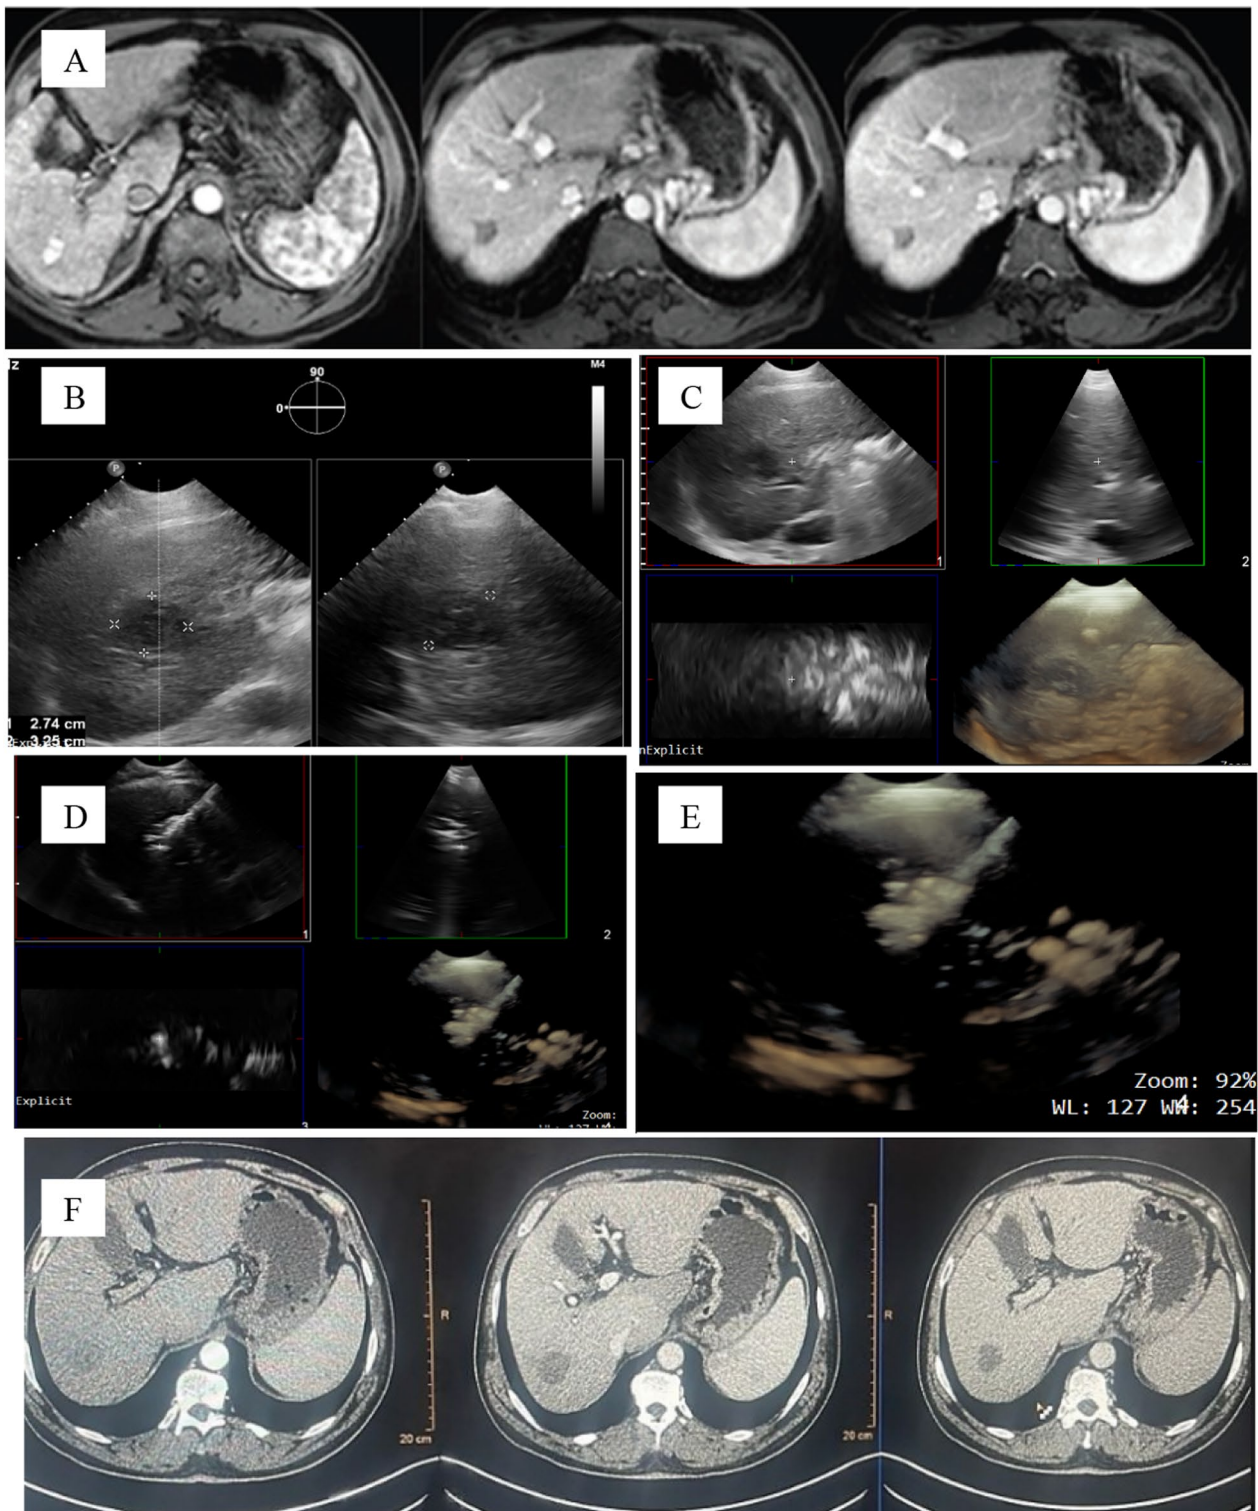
A–F, Case (4): A male patient with a right hepatic lobe segment VII focal lesions 2 × 2 cm, confirmed to be HCC by triphasic CT, A Triphasic CT scan showing arterial enhancement at the arterial phase and washout at the delayed phase, the patient was planned for US-guided RFA using X matrix probe guidance. B, C X plane images, 3D and volume rendering images of the hepatic focal lesion at right hepatic lobe segment VII D, E showing the tip of the needle inside the hepatic focal lesion at the X plane, 3D and volume render images, radiofrequency ablation was done under X matrix probe guidance (F)—Triphasic CT was done after one month, there was no enhancement at the arterial phase denoting adequate management according the Mrecist criteria
